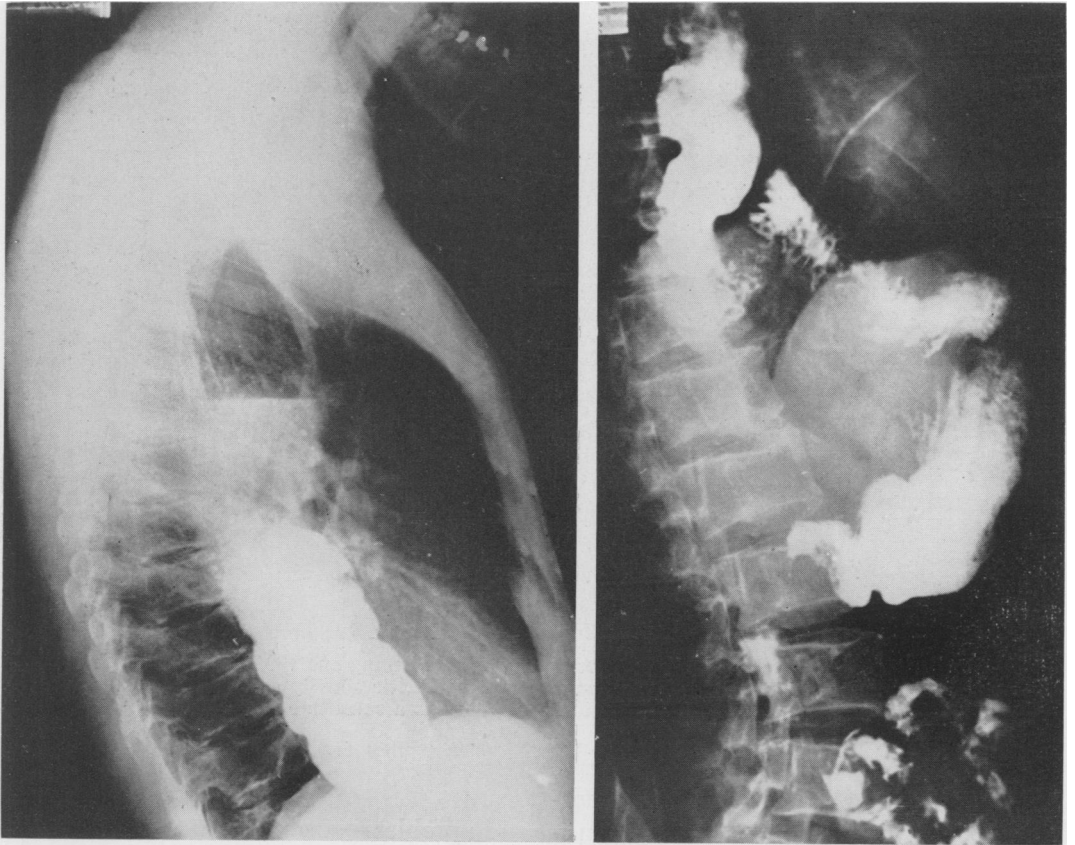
(G. H., Case 9.) *Left.* A preoperative side view of this patient with cardiospasm. *Right.* A postoperative roentgenologic study with the patient in approximately the same position following sphincter substitution by an interposed jejunal segment.
